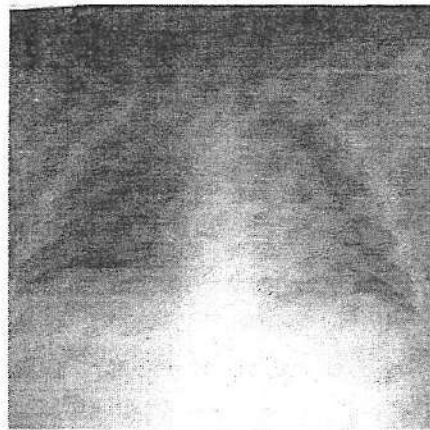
Chest Radiography AP
